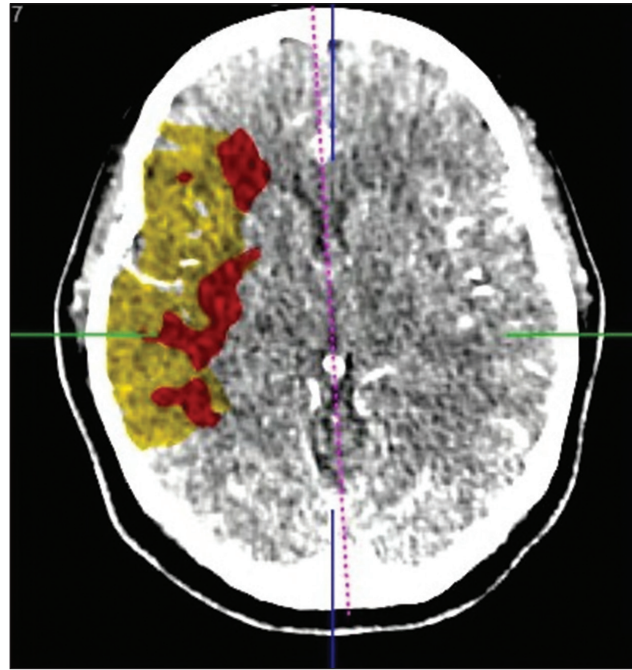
Head CT with perfusion showing significant penumbra area
